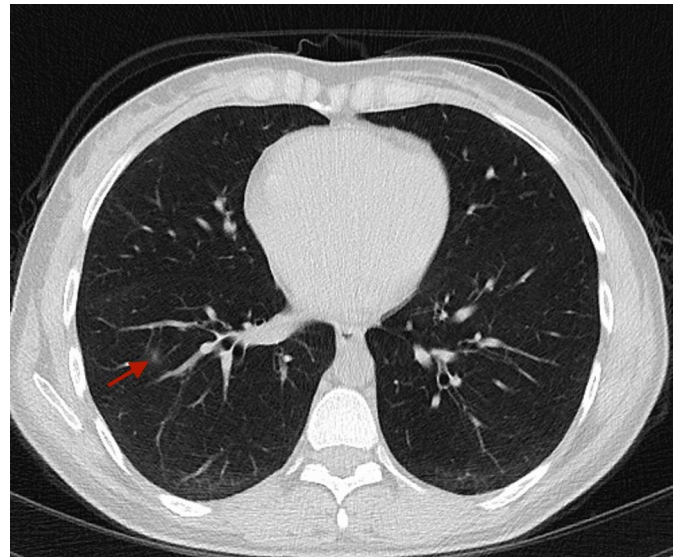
Round shaped ground glass opacity is observed in the lower lobe of the right lung on axial chest CT image (red arrow)
